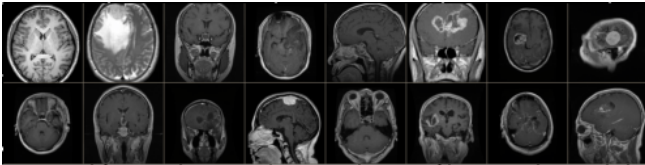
Collection of 16 CT-scan samples.
